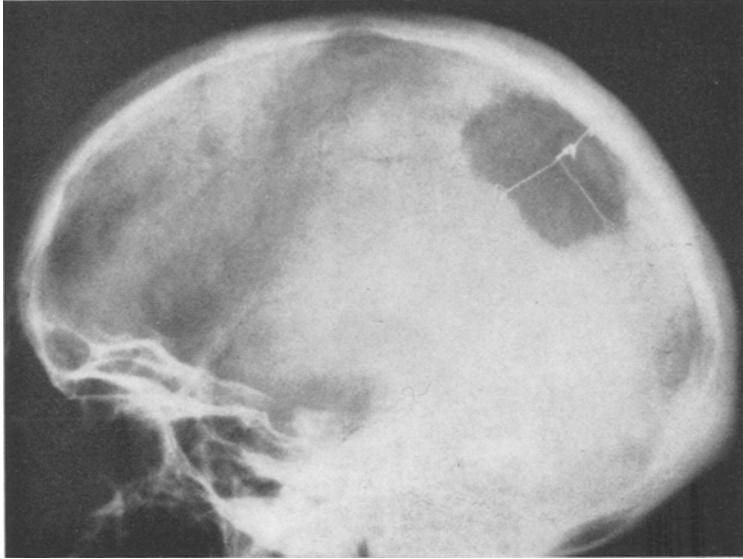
Lateral skull x-ray showing fixation wires.
